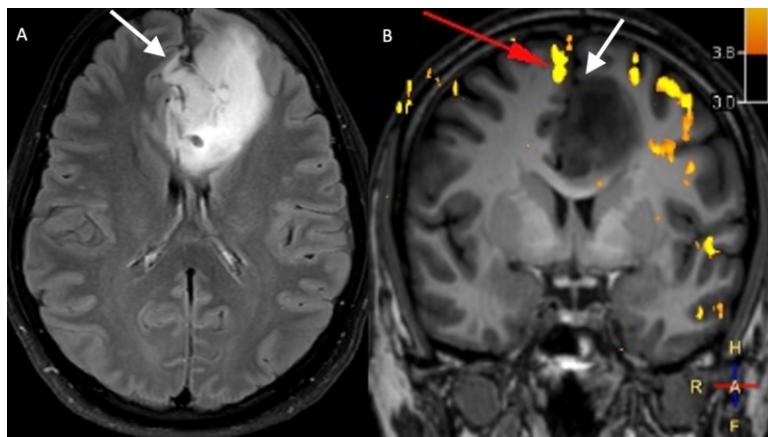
(A, B): Left frontal glioma. Axial T2W image shows the left frontal tumor (arrow). A functional MRI (B) was performed for motor mapping prior to surgery. The coronal BOLD image (B) shows that the foot activation area (red arrow) abuts the tumor (white arrow). The surgeon approached from the lateral aspect.
